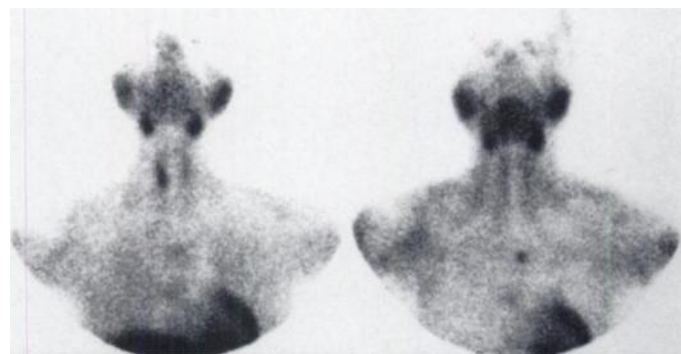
Technetium-99m-MIBI scintigraphy of Patient 1. On the delayed image (right) there is increased focal uptake in the mediastinum corresponding to a parathyroid adenoma of 660 mg.
